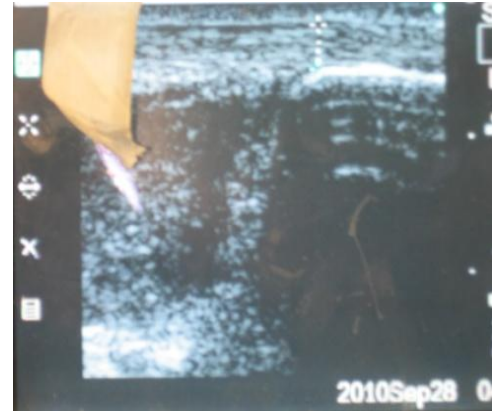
Sonogram showing longitudinal scan of Achilles tendon. Calipers indicate the measurement of tendon thickness
